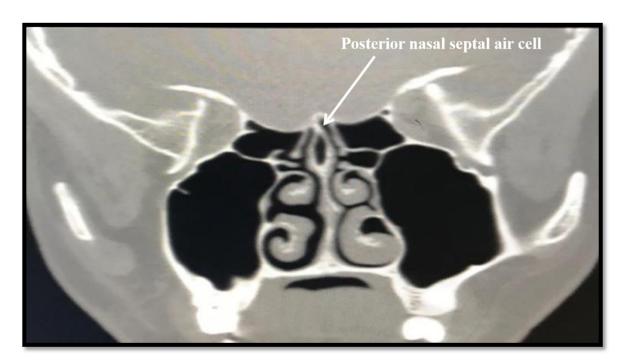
Coronal view of CT-PNS showing posterior nasal septal air cell in symptomatic patient of sinusitis (a rare anatomical variant of sinonasal region)
